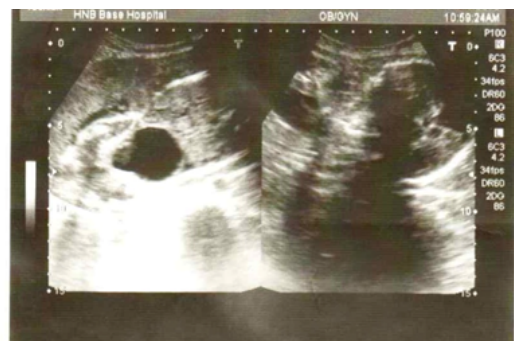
Sonography image showing PU valves with key-hole sign of an obstructed fetal urinary bladder.
